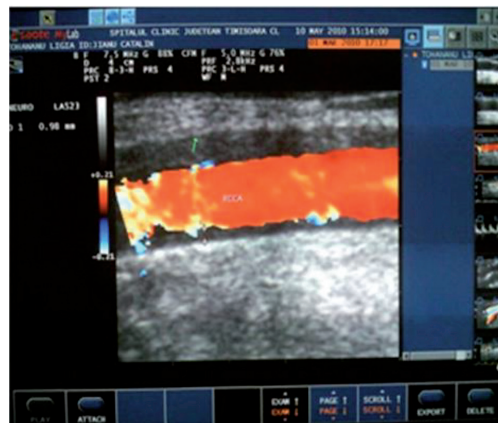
Large vessel GCA, color Doppler ultrasound in longitudinal view of the right CCA with hypoechoic wall swelling [4].
